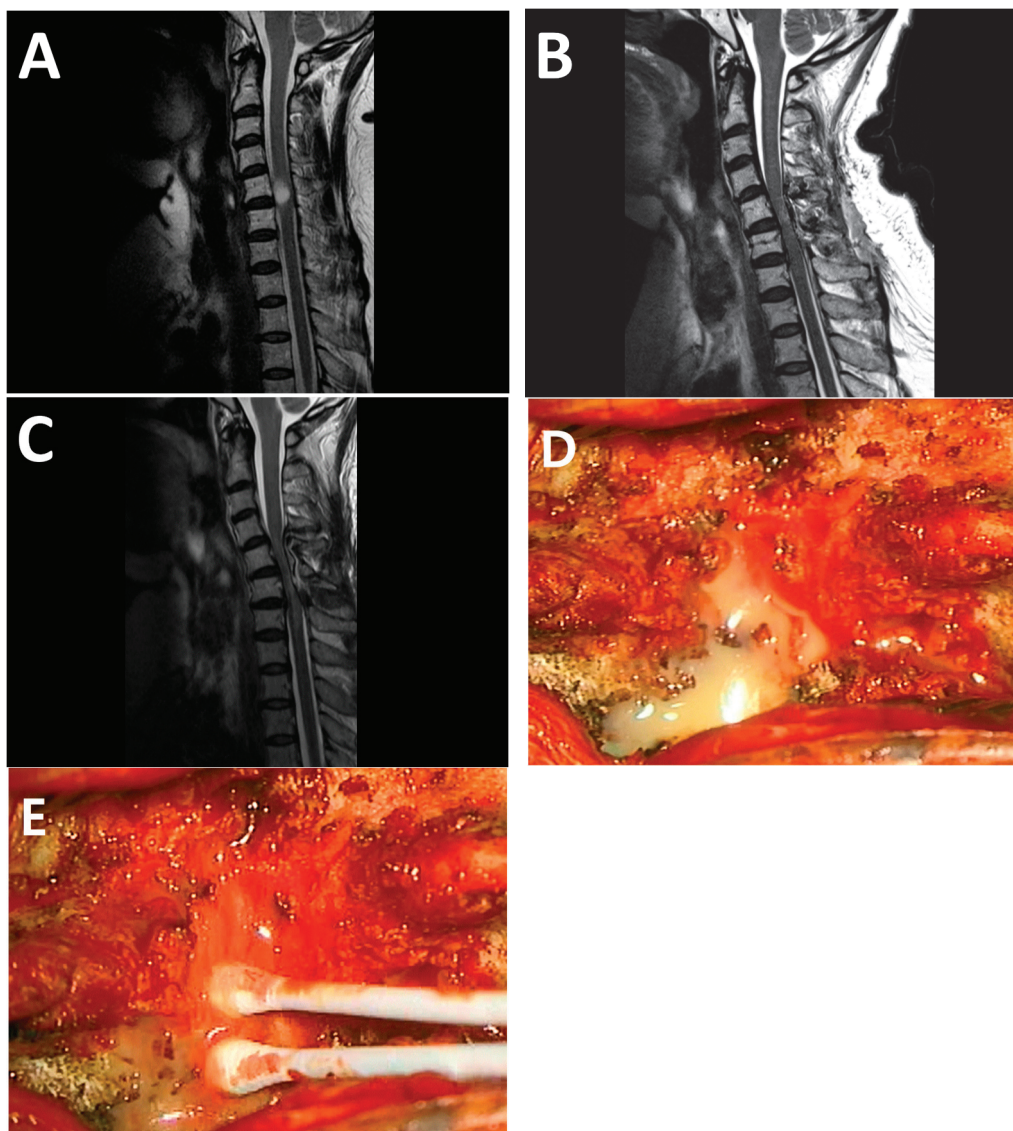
Representative cases of symptomatic cord compression and revision surgery. A 50-year-old female patient was diagnosed with an intradural spinal cord tumor at C5-6 level (A) and underwent laminoplasty laminotomy at C5-6 with resection of the intradural spinal cord tumor. Postoperative MR revealed no residual tumor (B), and pathology confirmed the tumor as a neurofibroma. Two months postoperatively, the patient experienced weakness in all four extremities, and a follow-up MRI confirmed a severe cord compressing lesion (C), leading to her readmission for further evaluation. Initially, a laboratory study was conducted under the suspicion of a postoperative abscess, but it found no clinical signs or lab abnormalities suggesting an infection. Ultimately, diagnostic revisional surgery was performed. During the revision surgeries, a mass compressing the spinal cord was identified, accompanied by yellowish fluid and moderate to severe spinal cord adhesions (D). However, culture studies of the yellowish pus in the postoperative state did not detect any specific bacteria or signs of infection (E), discontinuing the empirical antibiotics used initially.
